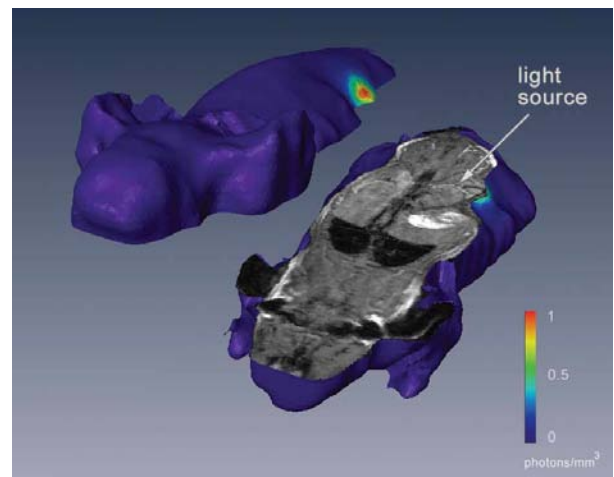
Combined BLI and MRI image. The luminescence scale was normalized to the peak intensity.
